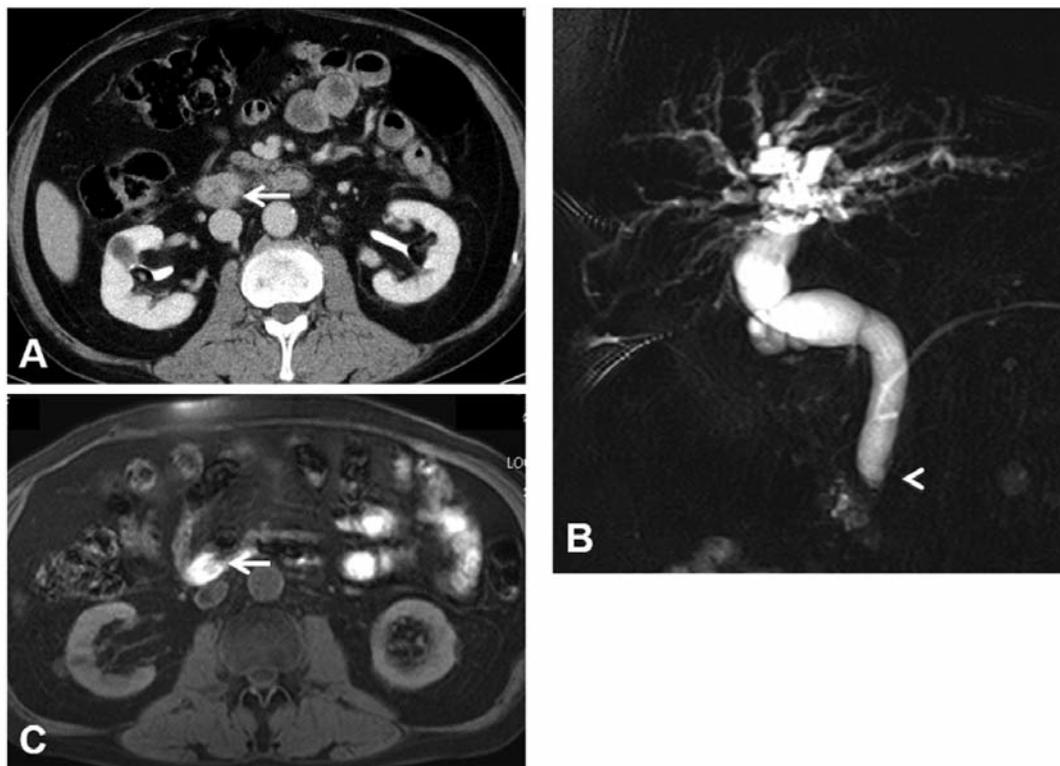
Computed tomography (CT) showed a nodule in the lower bile duct, which was slowly enhanced on dynamic CT (A, arrow). Magnetic resonance cholangiopancreatography (MRCP) revealed post-cholecystectomy state, dilatation of intra- and extra- hepatic bile duct (B, arrowhead) and a space-occupying lesion, which showed slight high intensity on fat suppression T1-weighted images (C, arrow).
